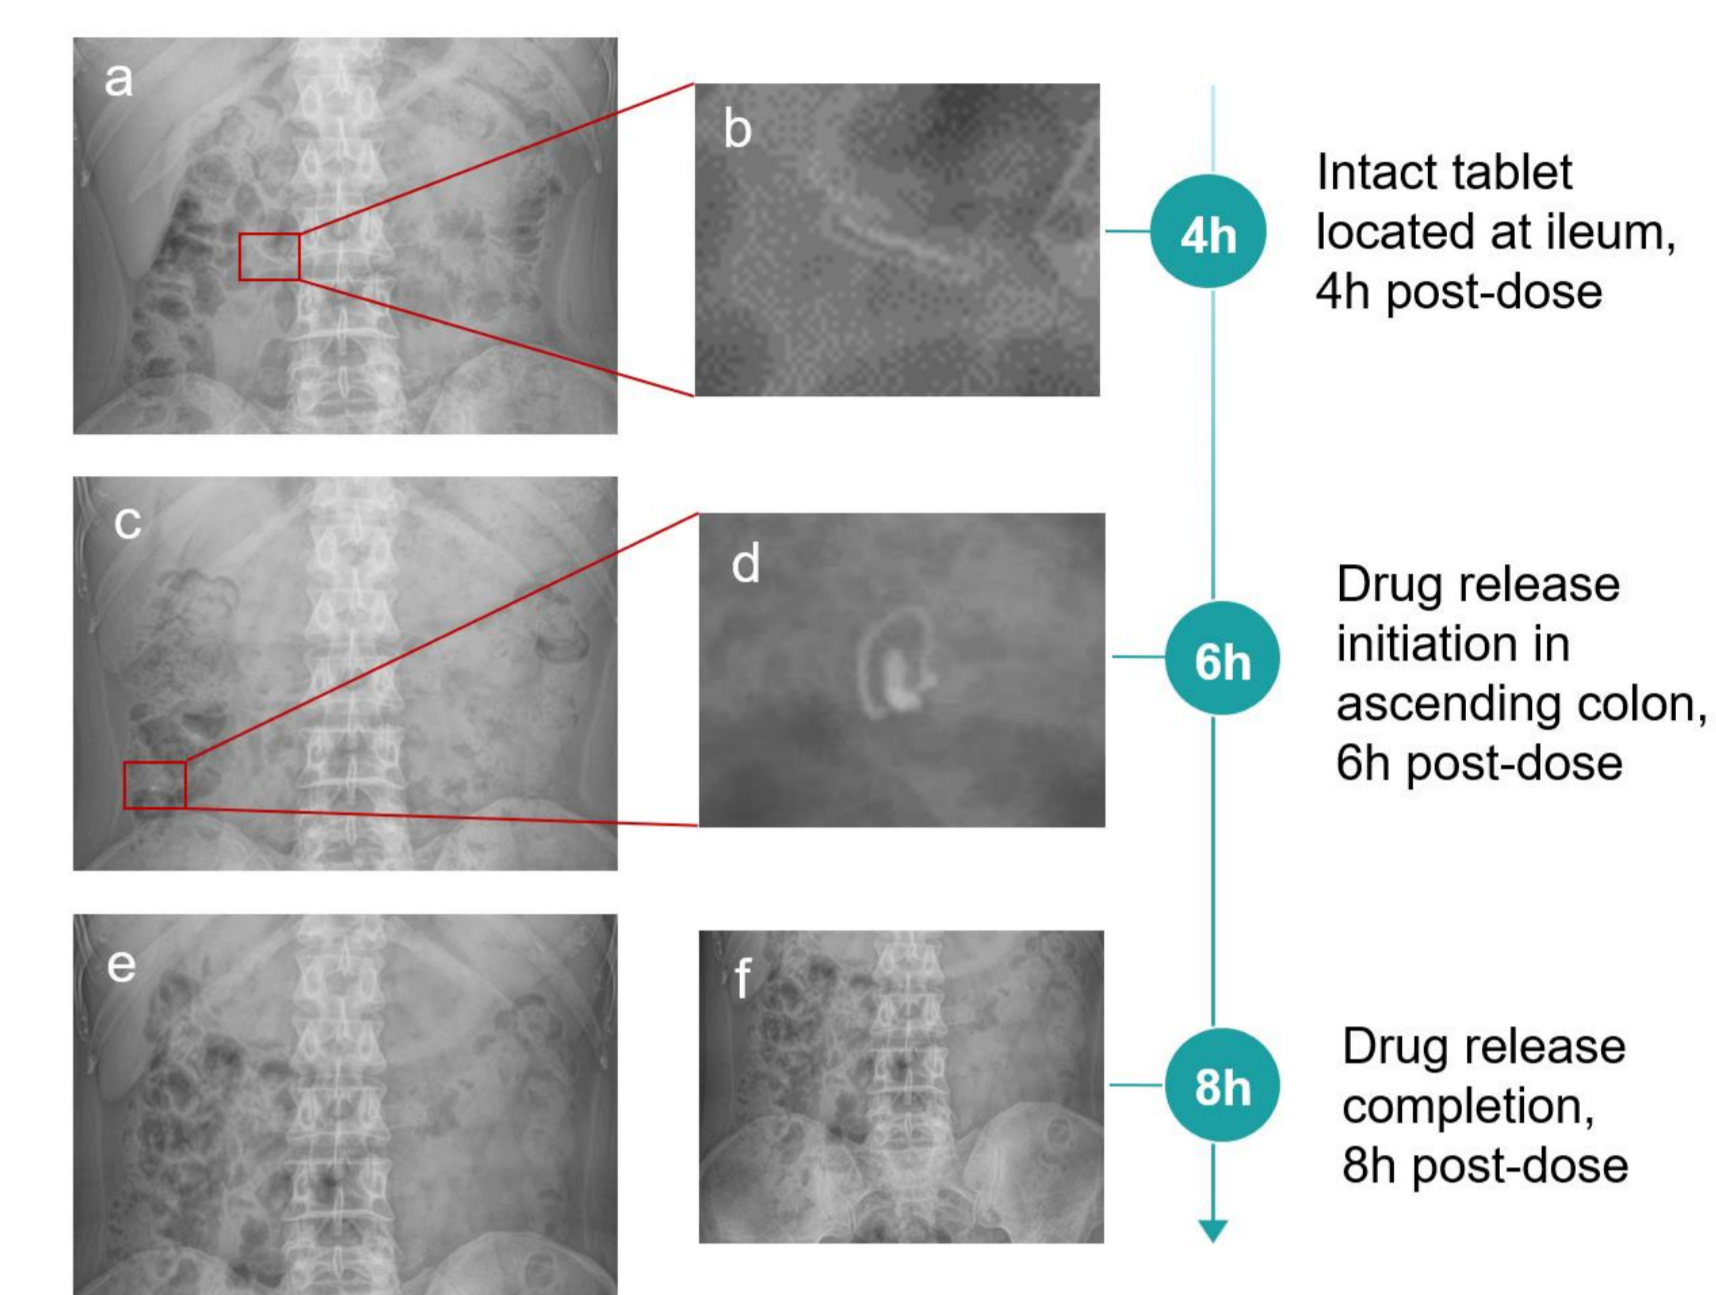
Representative X-ray images of one subject following Tablet 2 administration (a,c,e) whole abdomen images; (b,d,f) zoom in images.
